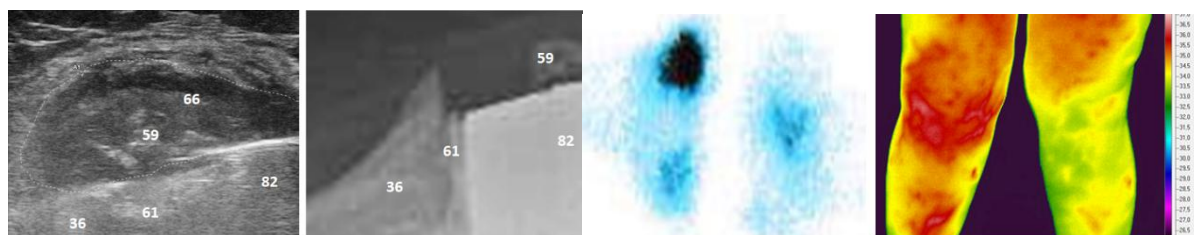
sono, Fig.10b.X-ray, Fig.10c.scinti, Fig.10d.TMV. Sono, X-ray: defect between femoral component of TEP and femur, ganglion with ossification above. Scinti: increased uptake of radiopharmaceutical in the TEP area on the right. TMV: increased thermal activity of the right knee. 36. femur, 59. calcification, 61. defect, 66. ganglioma, 82. TEP.
